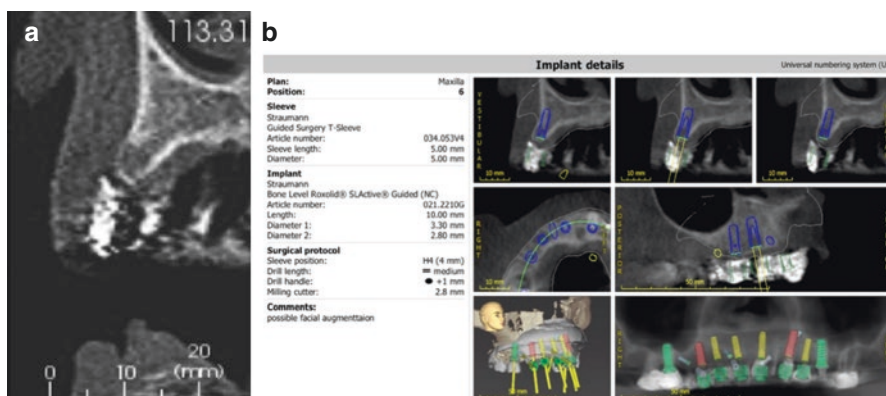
(a) A cross-section from a CBCT of a proposed implant site. An opening in the radiographic template indicates the relation of the proposed final crown to the implant site. (b) A digital implant has been placed and related to the proposed final position of the crown and bone. The process was repeated in the other proposed implant positions
